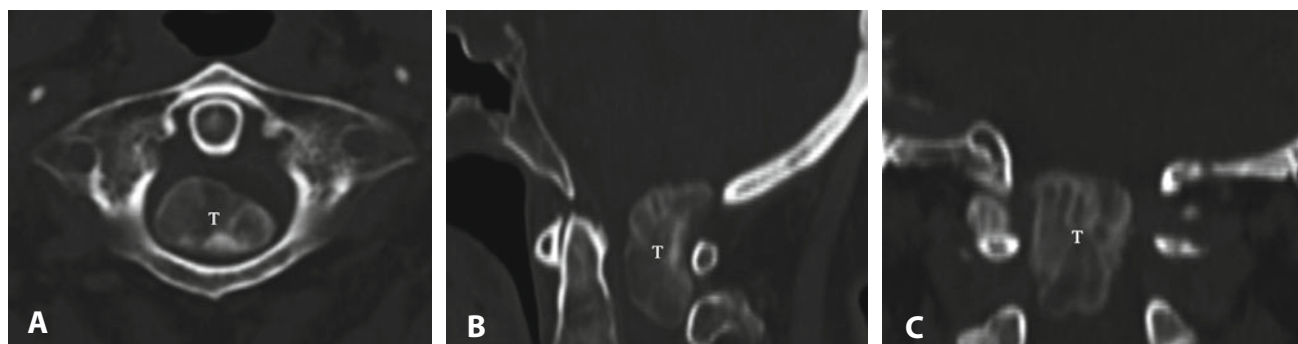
Large lateral foramen magnum meningioma. A–C. Preoperative pictures in axial (A), sagittal (B), and coronal (C) views. In A, notice the anterolateral displacement of the neuraxis because the lesion grows behind it, contrarily to anterior foramen magnum meningiomas. D–F. Postoperative control. D. Postoperative axial CT scans at the posterior fossa (D) and C1 (E) levels showing the extension of bone opening for the approach. One-fifth of the posterior aspect of the right C1 lateral mass has been removed to obtain a tangential access along the lateral dura mater. F. 3D angio-CT reconstruction showing the view that can be obtained by this approach if the neuraxis is displaced. The arrow indicates the level of the distal dural ring where the VA V3 segment enters the dura mater of the foramen magnum. C1 LM: lateral mass of atlas. C1PA: posterior arch of atlas. N: neuraxis. T: tumor.
